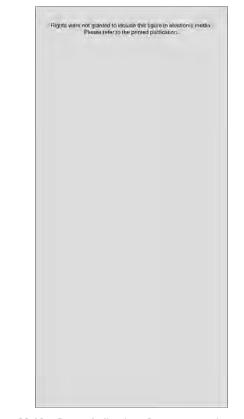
Gas embolization. Postmortem radiograph of a premature infant who died suddenly while requiring high ventilatory pressures. Gas can be seen within the heart and in some intra-abdominal veins. (From Bancalari E, Goldman SL. In Milunsky A, Friedman EA, Gluck L [eds]: Advances in Perinatal Medicine. New York, Plenum, 1989, p 129.)
